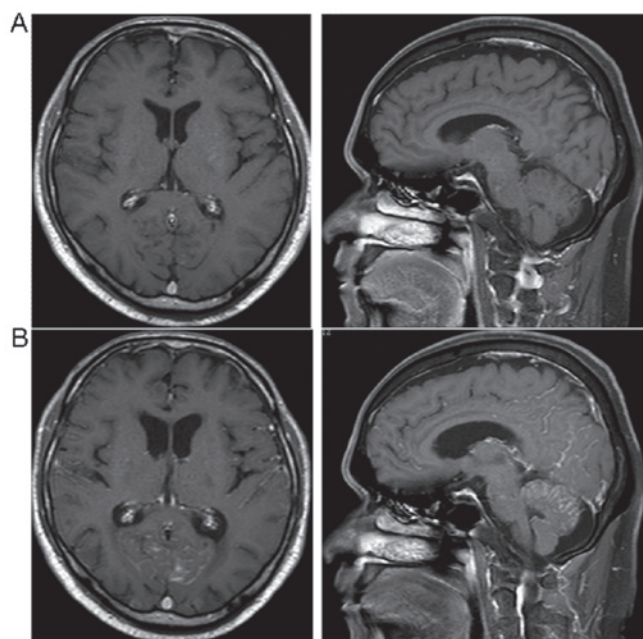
T1-weighted MRI of the brain with gadolinium enhancement. (A) August 16, 2011. (B) October 3, 2011, showing signal hyperintensity in the leptomeninges.
